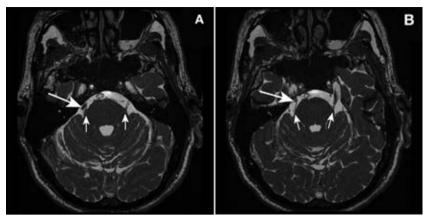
MRI of the posterior fossa of the brain showing neurovascular compression. Sequential, 0.8 mm, fine cut axial images from a volumetric T2 MRI acquisition on a patient with right sided trigeminal neuralgia. Caudal (A) and rostral (B) axial images shown. Origin of the trigeminal nerve from the brainstem on both sides is indicated by small arrows positioned along the course of the nerve. Inferior and lateral compression of the right trigeminal nerve route by a flow void representing the superior cerebellar artery is indicated by large arrows positioned perpendicular to the nerve course. The trigeminal nerve root is not only contacted but also displaced medially in its cisternal course by the superior cerebellar artery (B)
